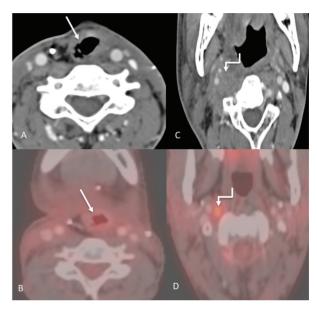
Post treatment imaging. Axial CT image (A) of a post laryngectomy patient showing the altered anatomy postsurgery (straight arrow) with a corresponding PET CT image (B) showing no significant uptake to suggest recurrence at the locoregional site. However, an enlarged right retropharyngeal node is seen on axial CT image (C), (marked with shouldered arrow) which also showed uptake on the corresponding PET CT image (D).
